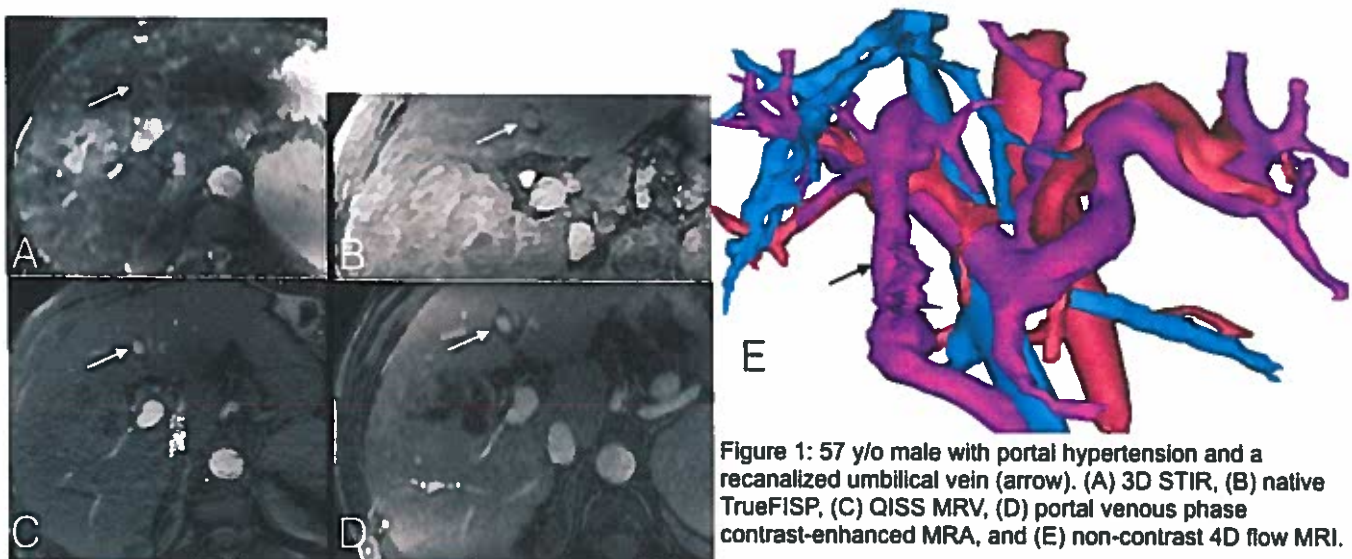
57 y/o male with portal hypertension and a recanalized umbilical vein (arrow). (A) 3D STIR, (B) native TrueFISP, (C) QISS MRV, (D) portal venous phase contrast-enhanced MRA, and (E) non-contrast 4D flow MRI.
